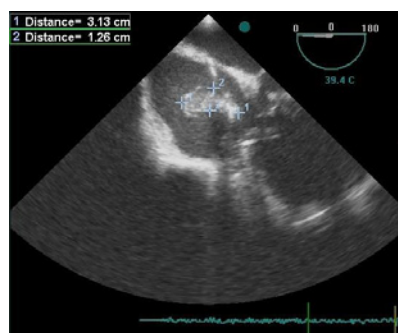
On transesophageal echocardiography was performed showing this giant mobile mass attached to the intracardiac pacemaker lead in the right atrium.
